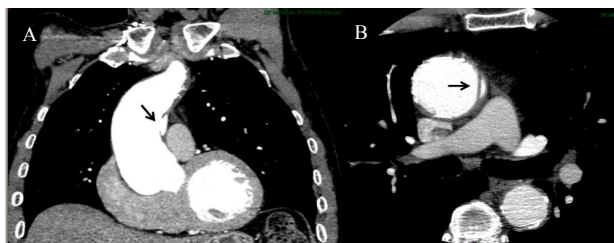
Preoperative computed tomography scan: (A), sagittal view; (B), axial view. Note the intimal tear without medial hematoma and eccentric aortic wall bulge (arrows).
